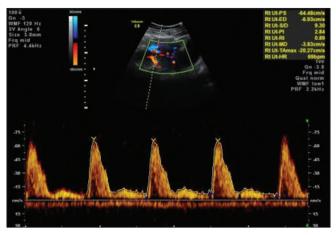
Doppler wave form of the right uterine artery showing raised resistive index and pulsatility index
